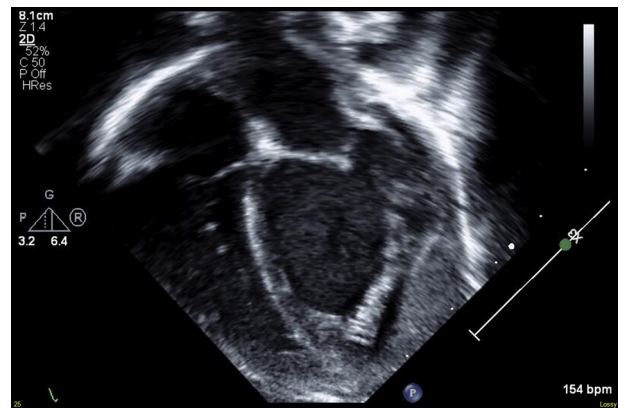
A fetal apical four-chamber view showing large intra-pericardial tumors and a pericardial effusion.
